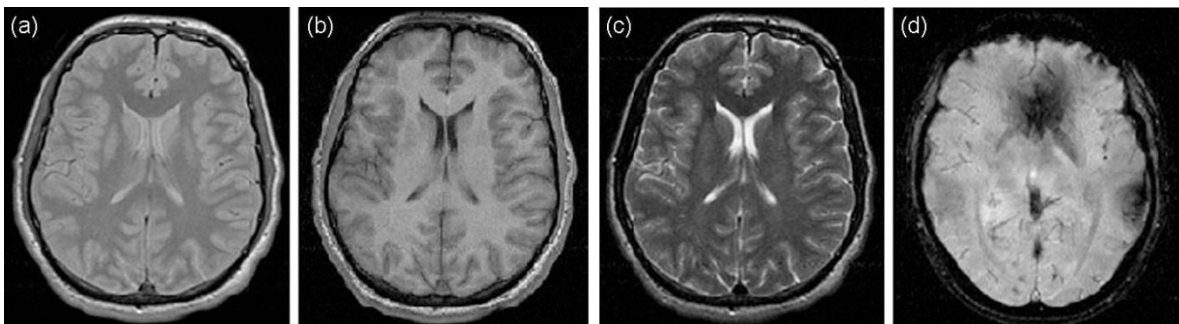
Different image contrasts of an axial brain slice at 3T: (a) Proton-density-weighted image (b) T1-weighted image (c) T2-weighted image (d) T2* -weighted image [258].
